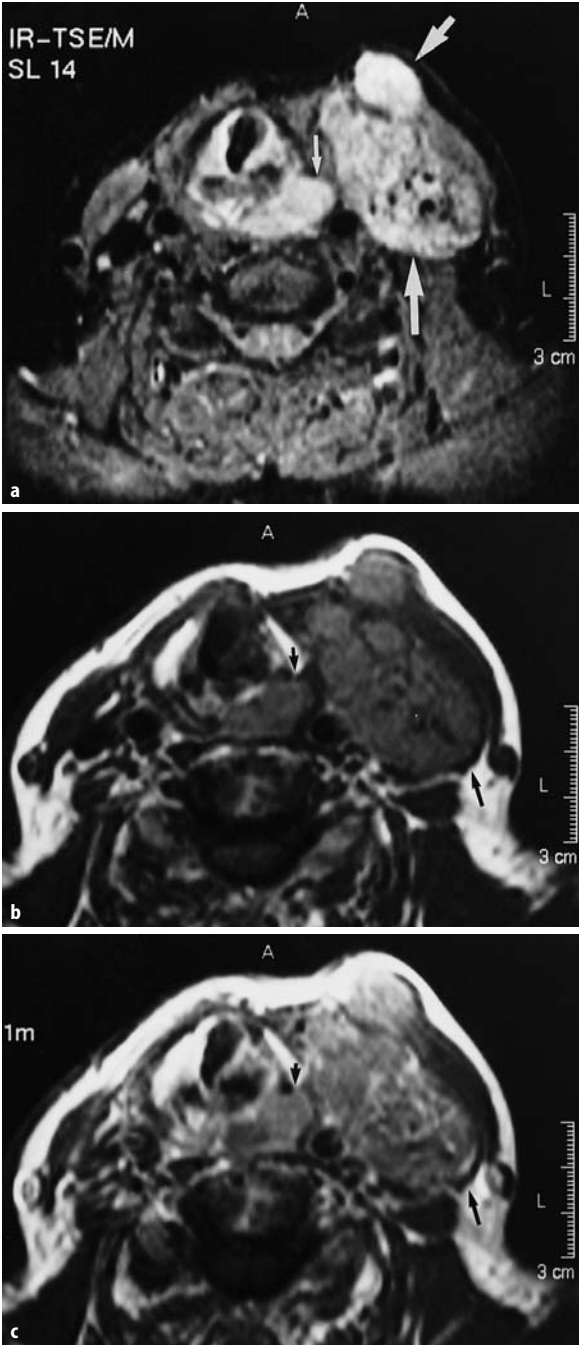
Primary left-sided follicular thyroid cancer with secondary dedifferentiation and a cranio-caudad extension of 10 cm. a STIR; b T1-weighted image; c T1-weighted post-Gd image: Inhomogeneous hyperintense mass with complex extensions to the ventral muscles and paralaryngeal space (arrows). The tumour tissue reaches the carotid artery with suspected invasion, the internal jugular vein is no longer distinguishable
